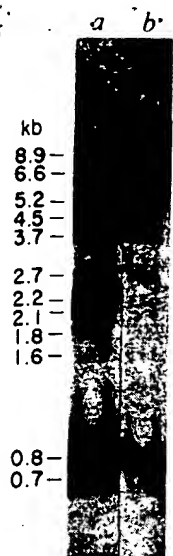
Southern blot analysis of A431 (a) versus placental (b) DNA. High-molecular weight chromosomal DNA was isolated as described³⁸. DNA (10 µg) was digested with excess *Eco*RI (New England Biolabs) then analysed by Southern blot hybridization. A mixture of all *Eco*RI fragments of λ HER-A62 and λ HER-A64 (as in Fig. 4) was radiolabelled with [α -³²P]dATP and [α -³²P]dCTP (Amersham) by the procedure of Taylor *et al.*⁶². Processed filters were exposed to X-ray film for 5 days at -70 °C using Cronex lighting plus intensifier screens. A phage DNA was digested with *Eco*RI and *Hind*III was used as a size marker.
